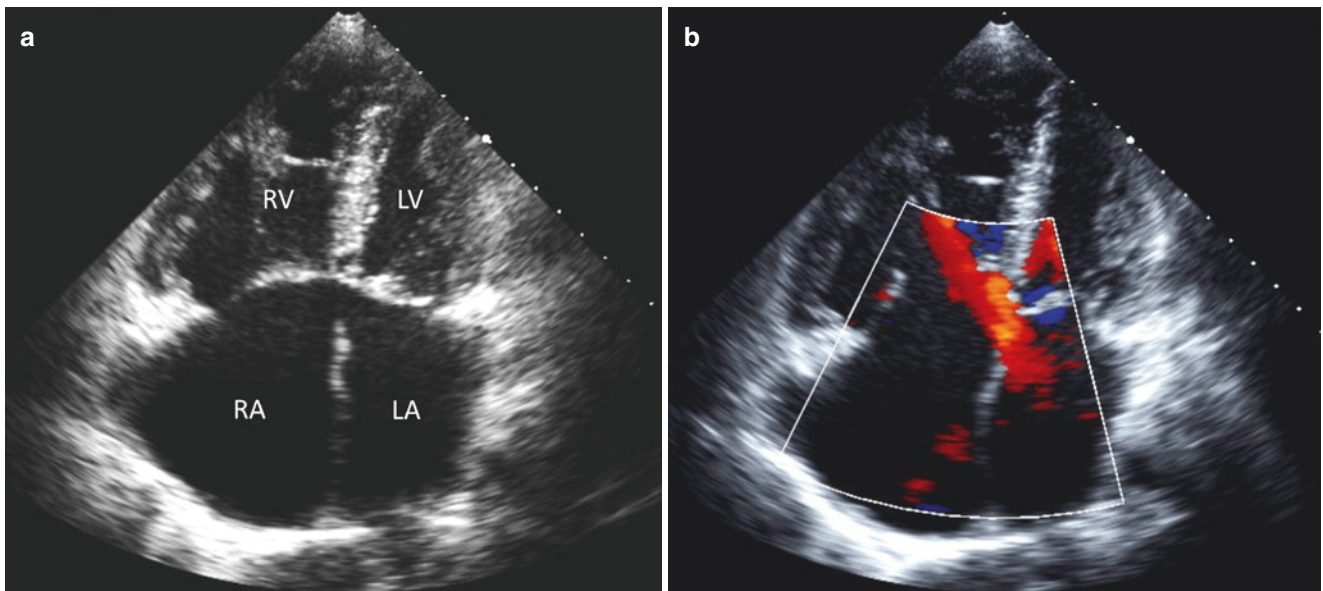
Ostium primum atrial septal defect. (a) Apical four-chamber view showing an ostium primum atrial septum defect. The probe is placed fifth left intercostal space, mid-clavicular line, angled toward the right shoulder; probe marker is at the 2–3-o'clock position. The atrial septal defect is located at the apical portion of the atrial septum (inferior limbus). Note that the right and left atrioventricular valves are on the same
